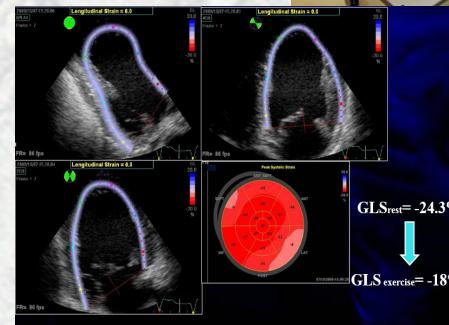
Assessment of global longitudinal strain at rest and during submaximal exercise in a patient with severe organic mitral regurgitation. Global longitudinal strain in the apical four-chamber view increased from  $-18.8\%$  to  $-25.5\%$  in this example.
